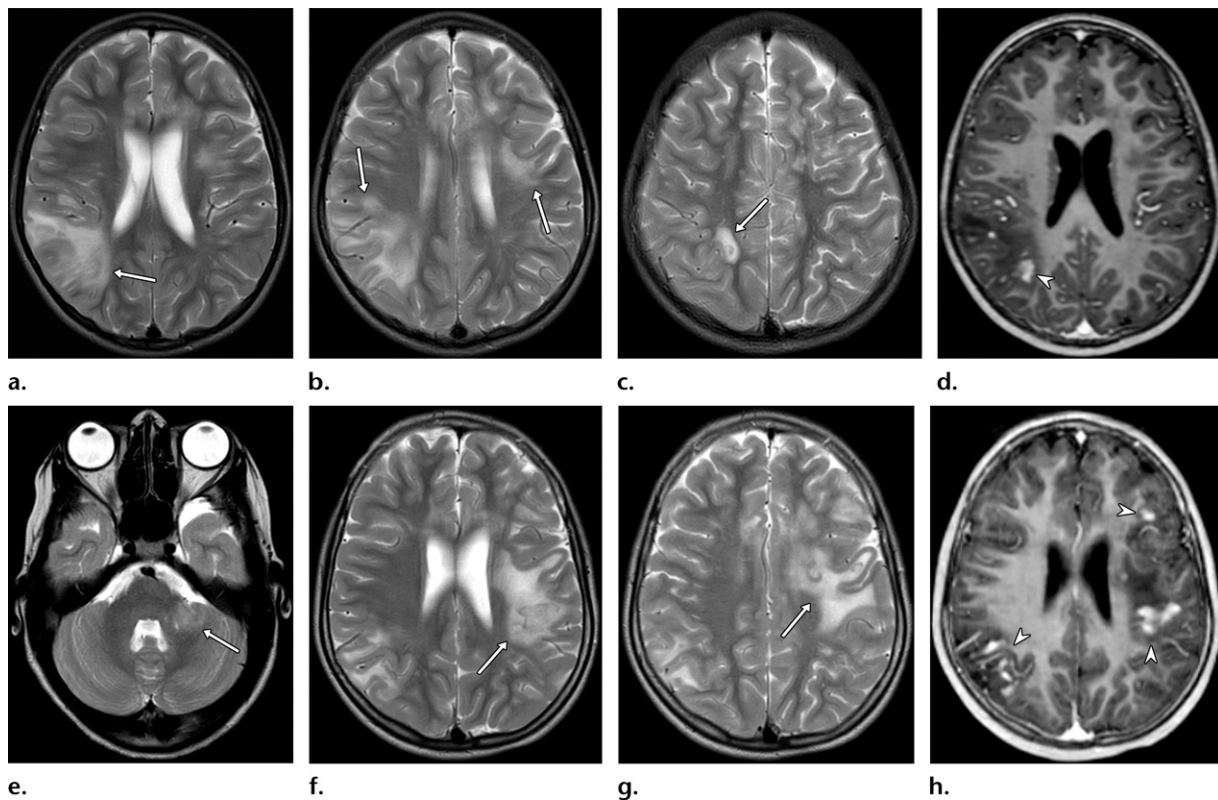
MOG antibody–associated MDEM in a 7-year-old girl with encephalopathy, fluctuating drowsiness, and irritability. She went on to have three relapses over the next 3 years. (a–c) Axial T2-weighted images at initial presentation show bilateral cortical and white matter lesions (arrows). (d) Axial postcontrast T1-weighted image shows an enhancing cerebral lesion (arrowhead). After 12 months of follow-up, MRI demonstrated near-complete resolution of all lesions (not shown). (e–g) Axial T2-weighted images at the first relapse 19 months later show multifocal bilateral but asymmetric white matter lesions including the left cerebellar peduncle (arrow). (h) Axial postcontrast T1-weighted image shows several punctate nodular enhancing lesions (arrowheads). Repeat MRI during clinical relapses at 22 months and 32 months revealed new confluent lesions involving the deep and subcortical white matter (not shown).
